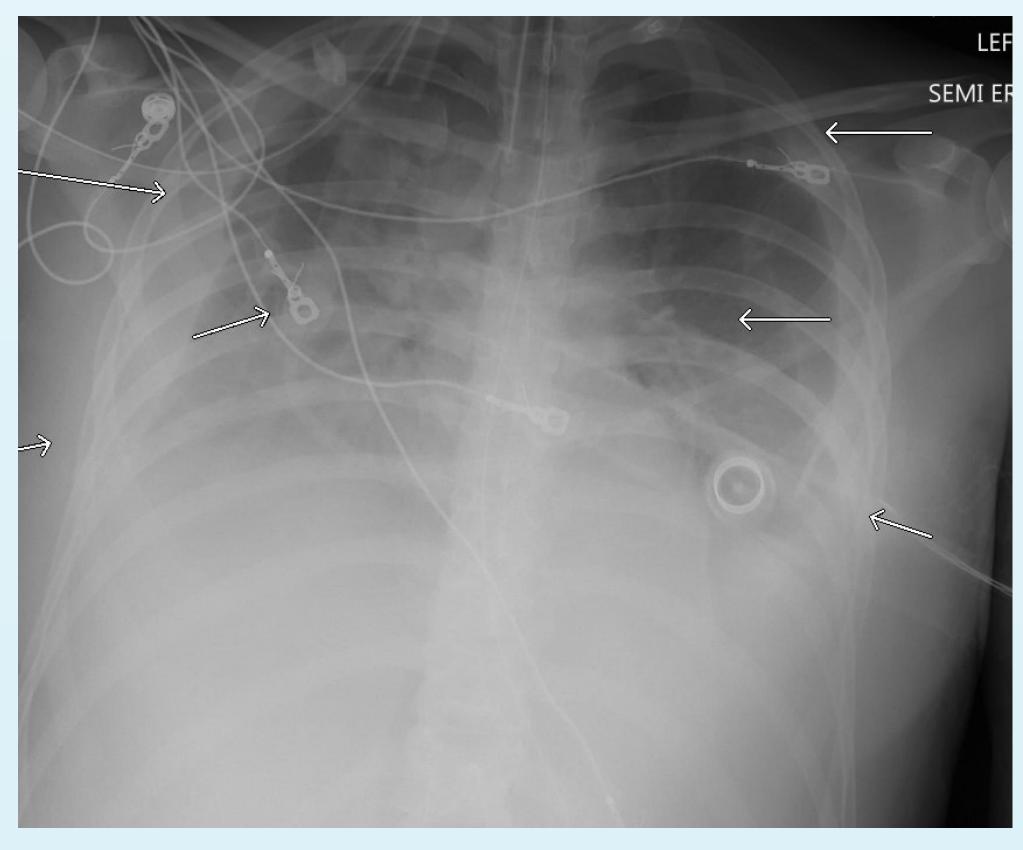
Radiograph of the patient's chest showing a large, bilateral pleural effusion
